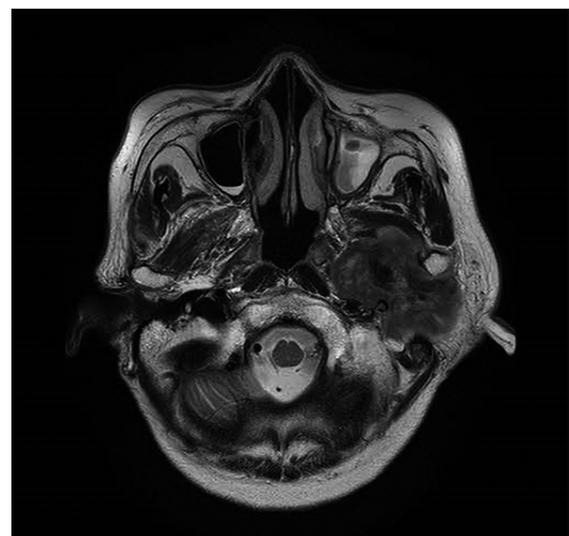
Axial T2-weighted magnetic resonance imaging show extensive tumor infiltration in the left masticator space causing bowing of the left lateral pterygoid muscle and extending to the left parotid gland.
